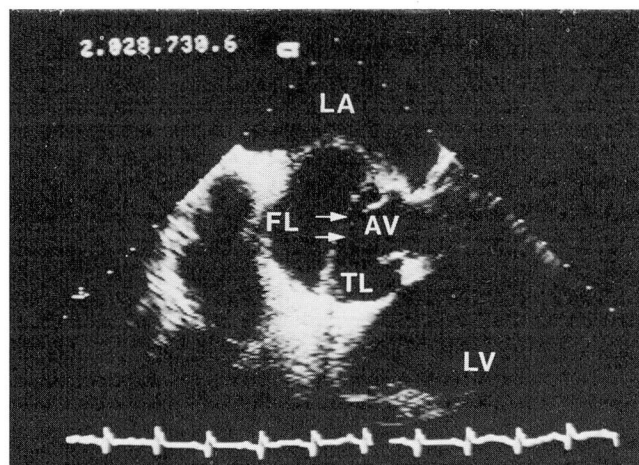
Transesophageal echocardiogram at level of aortic root showing dissection of the ascending thoracic aorta and intimal flap (arrows). FL = false lumen; TL = true lumen; AV = aortic valve; LV = left ventricle; LA = left atrium.
